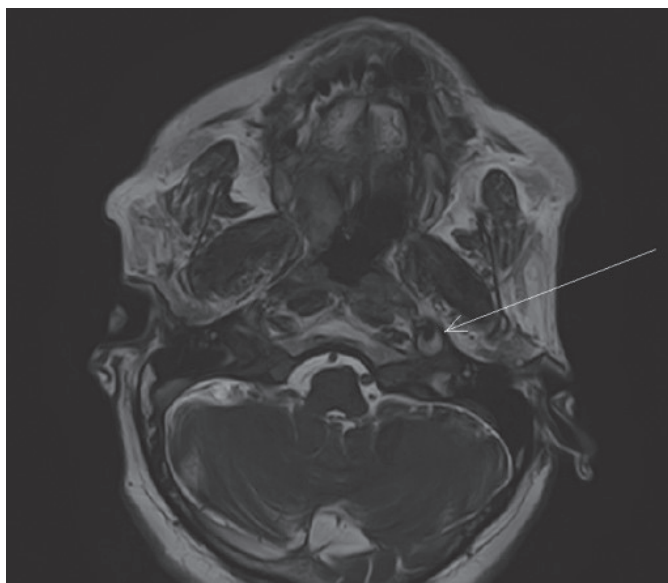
MRI TOF sequences T2. Semilunar aspect of the intramural hematoma at dissection level.
